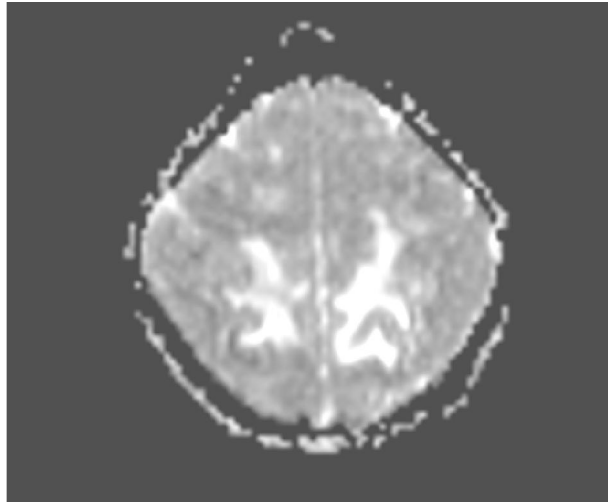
MRI ADC sequence: showing a hyperintense area in the posterior subcortical region of brain.
